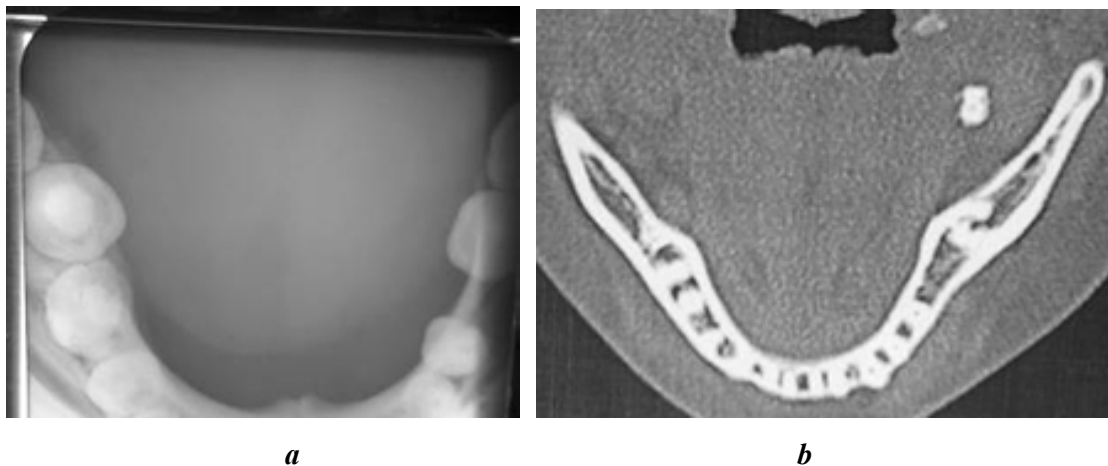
Visualization of concretions during overview radiography of the submandibular region. ([https://pandia.ru/text/77/512/images/image006\\_34.jpg](https://pandia.ru/text/77/512/images/image006_34.jpg))
